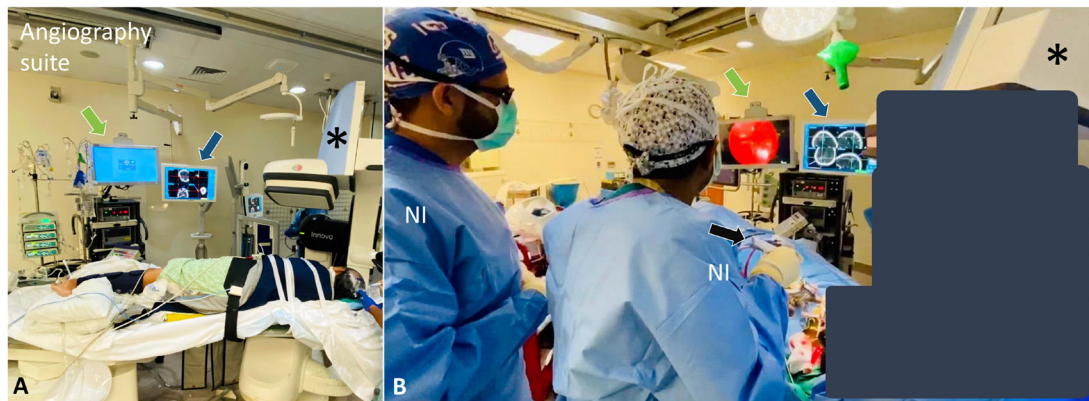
(A) Angiography suite set-up and patient preparation for minimally invasive surgery (MIS). (B) A proctored MIS procedure taking place using neuronavigation system (blue arrow) and Artemis device (black arrow). Light green arrow=endoscopic visualization screen; black asterix=frontal image intensifier used obtain flat panel CT images. Proctoring neurosurgeon not pictured. NI, neurointerventionalist.
